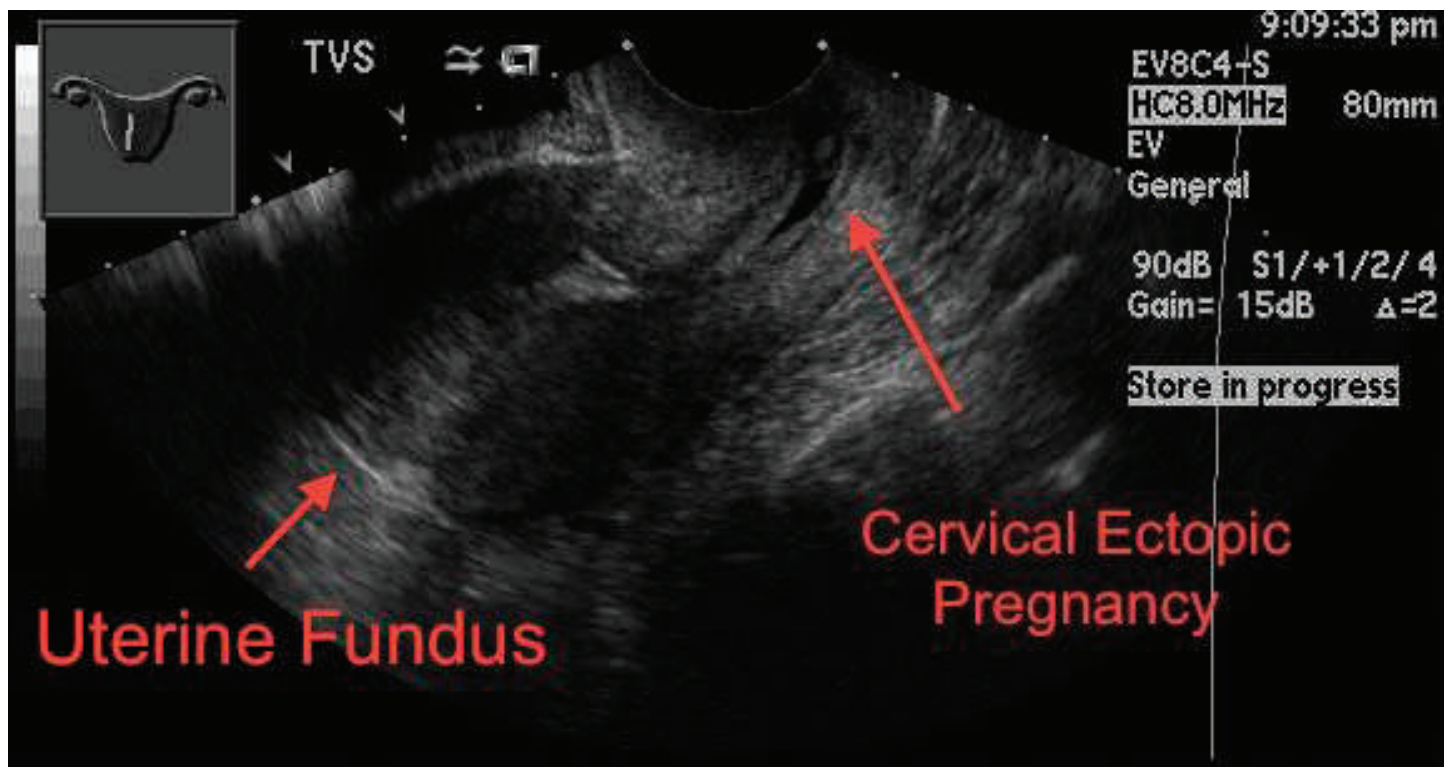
Transvaginal ultrasound in longitudinal plane.
